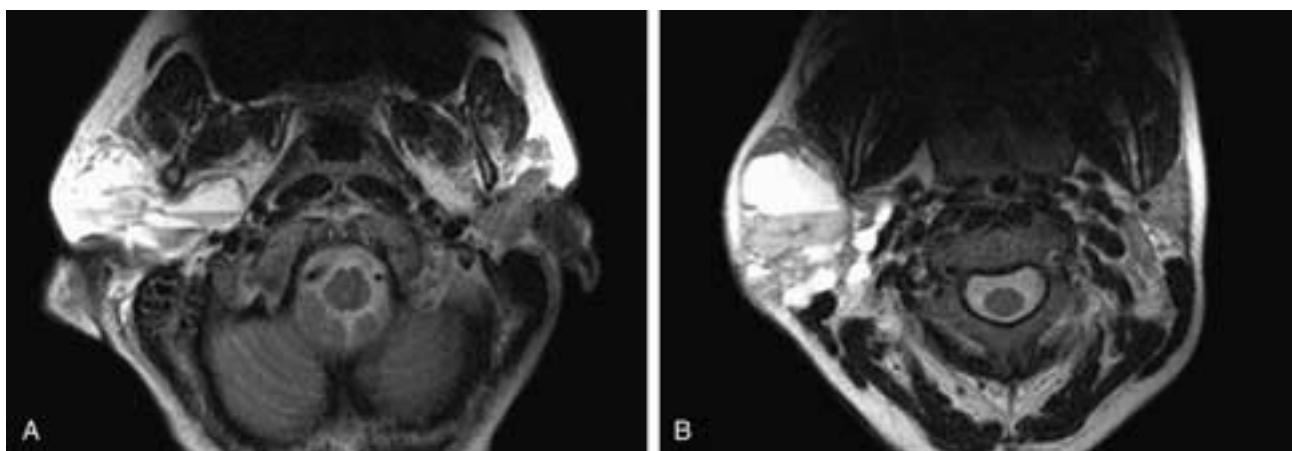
Axial T1-weighted, fat-suppressed, contrast-enhanced MR images (A, B) show a multicystic mass within the right parotid gland. Within the cysts there are fluid-fluid levels. This patient had a lymphangioma of the parotid gland.
